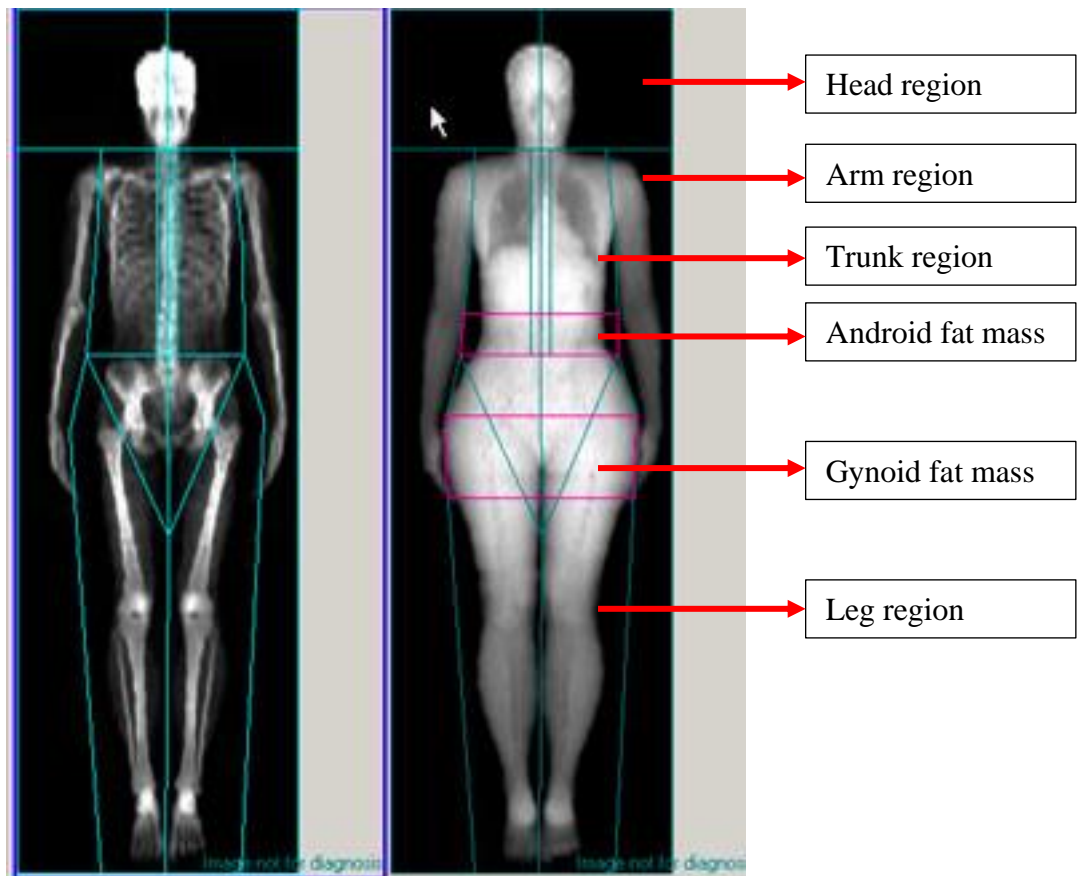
Regional body composition measurement by dual-energy X-ray absorptiometry (DXA). Regions of interest (ROI) in head, arm, trunk, leg, android and gynoid are shown in the right panel.
